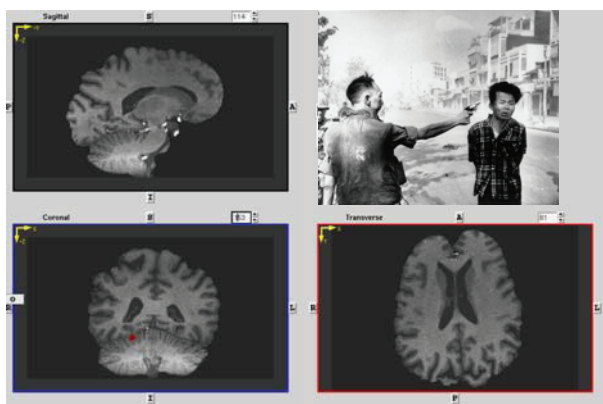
Functional MRI after six weeks of interferon in a representative subject who did not show interferon-induced activation. A representative section of the brain MRI at six weeks of one (AA) of the test subjects who did not develop any CNS symptoms after six weeks of interferon therapy. Visual stimulus #2 (Figure 2) was used to generate this scan. There are no significant areas of brain activation (red) over baseline (Figure 5). There was no significant change in the Beck Depression scale. This lack of activation was seen in all subjects who did not develop clinical depression while on treatment with INF.
